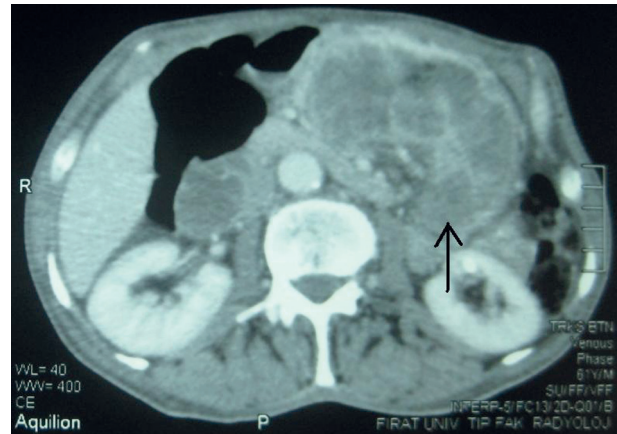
Computed tomography cross-section of a large necrotic tumor filled gastric body.
